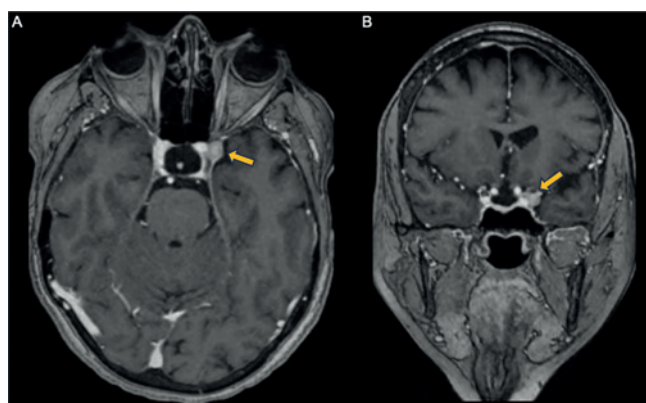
Brain MRI. Axial (A) and coronal (B) post-contrast T1-weighted images show an extra-axial lesion with homogeneous enhancement in the left cavernous sinus (arrows), extending toward the superior orbital fissure and in close proximity to the intracavernous segment of the internal carotid artery.
